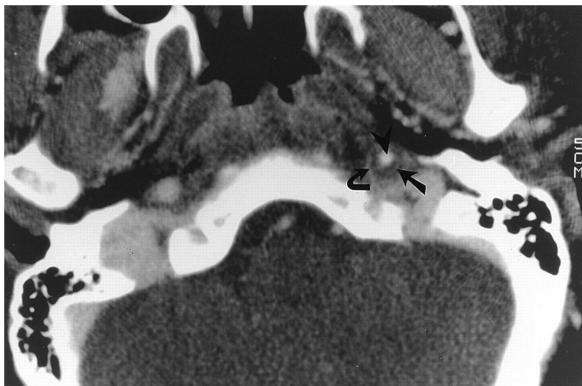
Typical target CT picture of dissection of the left internal carotid artery associating an arterial wall thickening (straight arrow) with a narrowed eccentric lumen (arrowhead) surrounded by a thin annular contrast enhancement (curved arrow).
